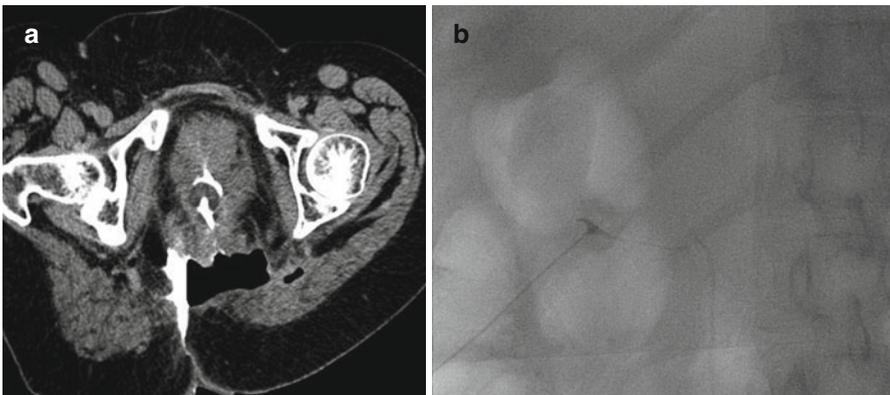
CT of the pelvis (a) shows contrast leaking into a large perineal wound. This is an indication for bilateral nephrostomies. Typically, the system will not be dilated. Ultrasound is used for the initial puncture, but fluoroscopy (b) is needed for placing the wire and catheter. Note that the calyx has been successfully punctured
